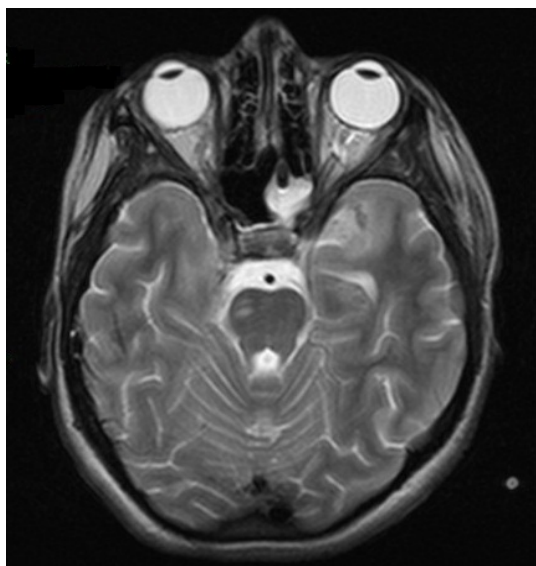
MRI sections (Day 7th) - focal lesions within the corpus callosum and the antero-lateral mezencefalic region
